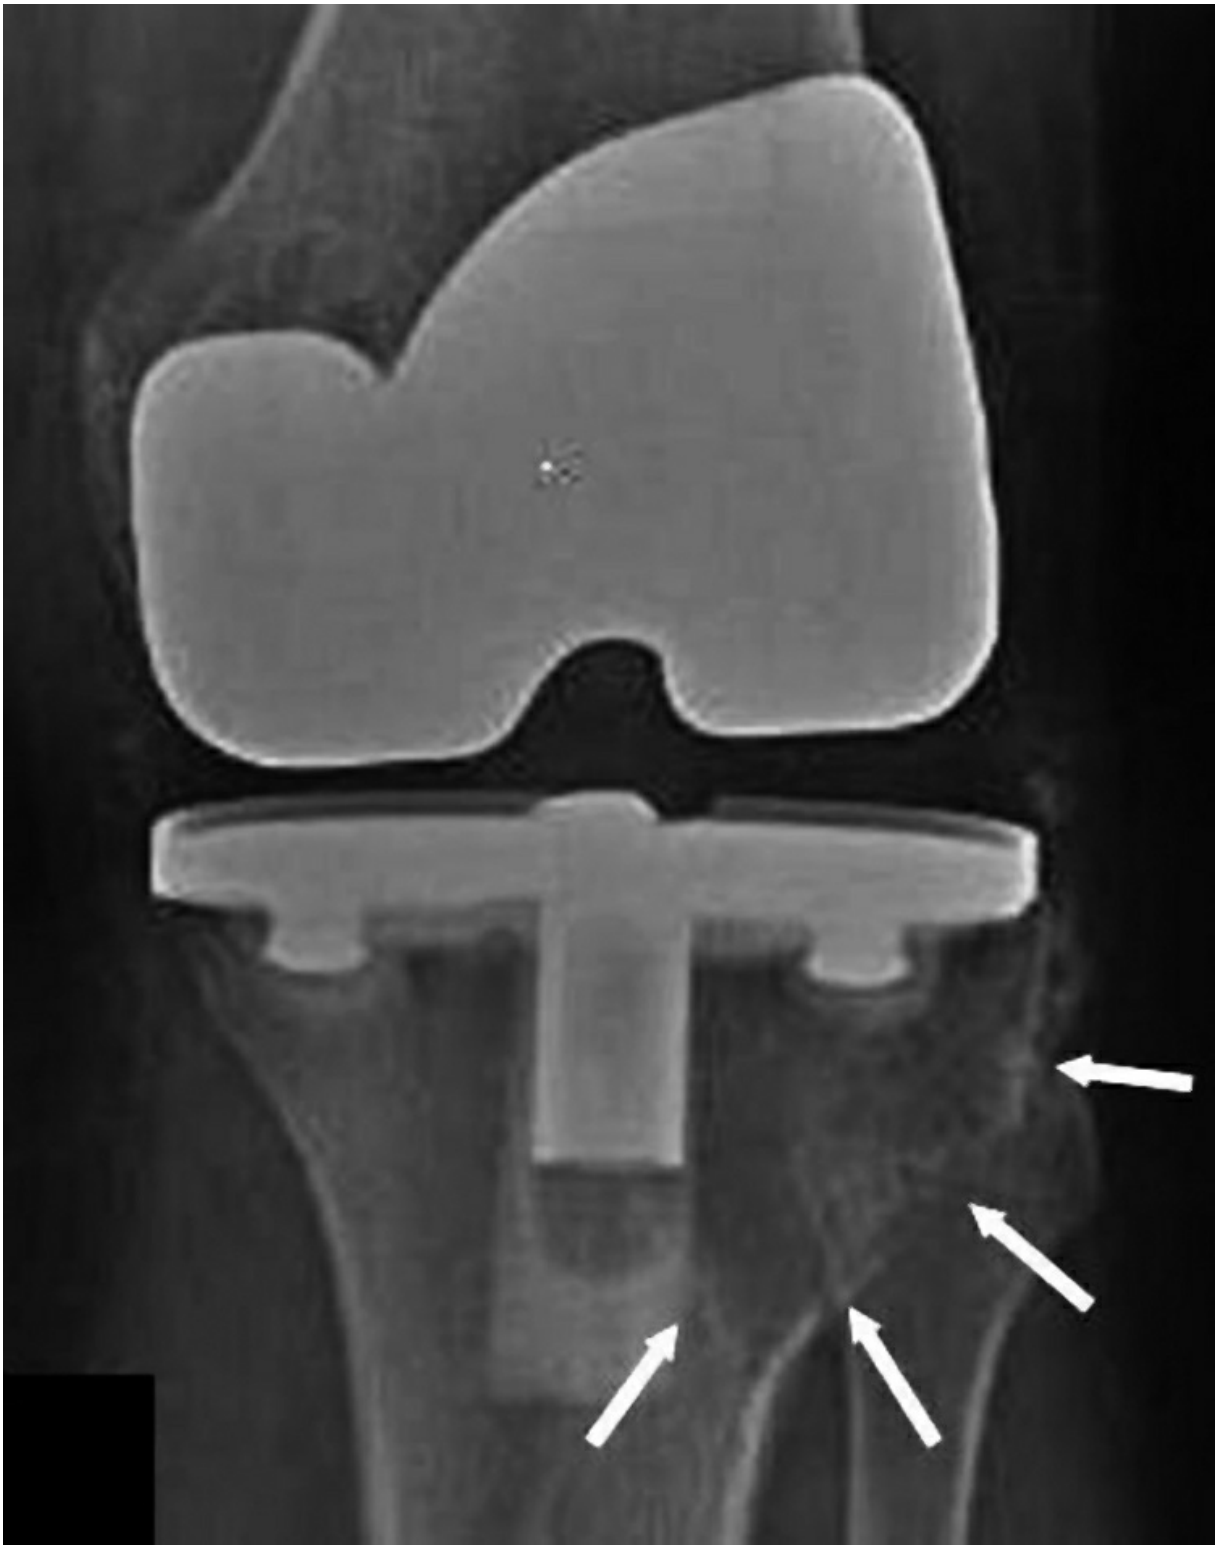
AP radiograph of the knee demonstrates particulate wear debris–induced osteolysis resulting in a well-demarcated uncontained lateral tibial defect (arrows).
